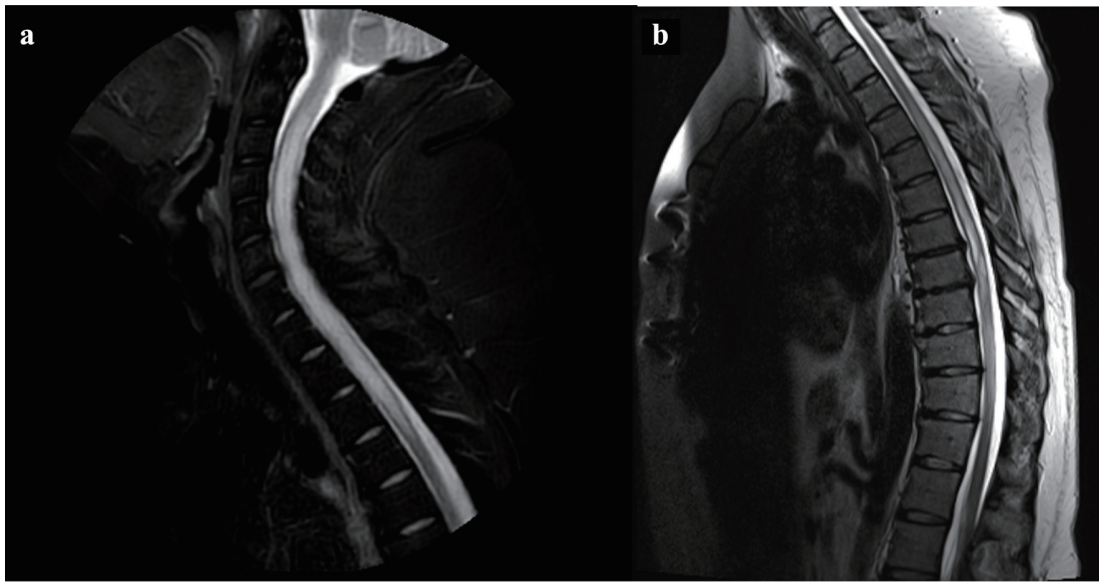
Sagittal spinal MRI demonstrating disease evolution. (a) Extensive cervical myelitis at NMOSD onset. (b) Follow-up MRI performed approximately 18 months later showing a new longitudinally extensive thoracic spinal cord lesion, consistent with ongoing disease activity.
